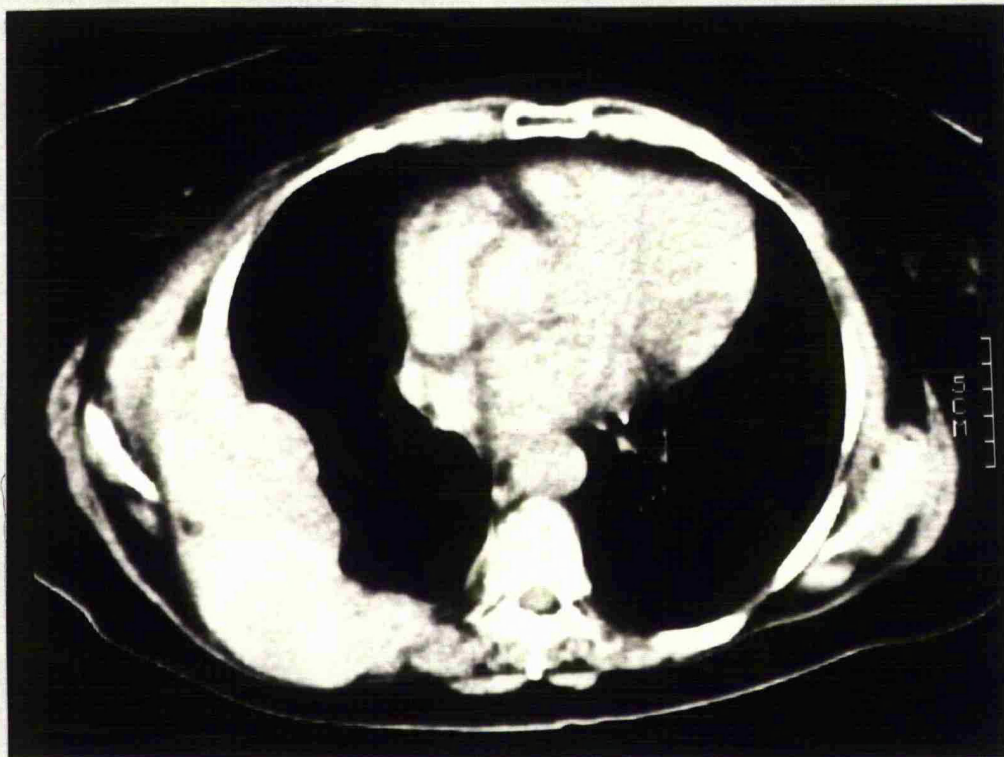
Unenhanced CT (above) of the thorax in a patient with a metastasis in the right chest wall. Below: perfusion image created using the Siemens prototype software.
